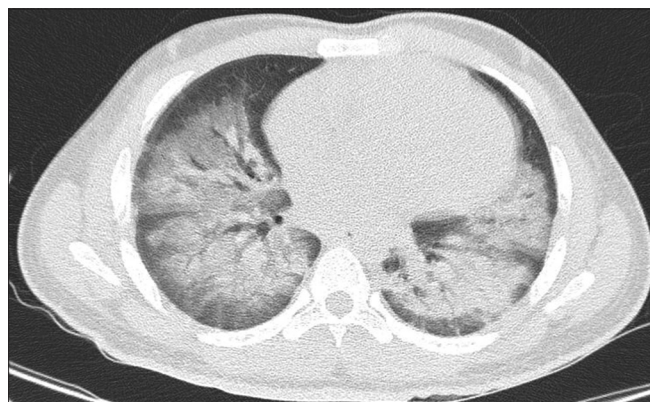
HRCT chest of the patient. HRCT: High-resolution computed tomography
